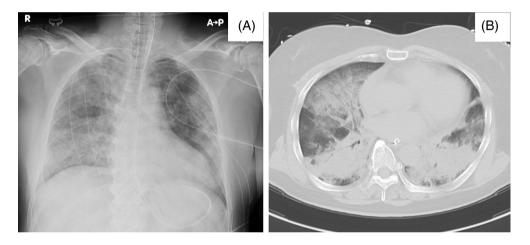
(A) Chest radiographs on admission showing diffuse infiltration in lungs bilaterally and (B) computed tomography on admission shows diffuse consolidations with dorsal predominance and ground-glass opacity
